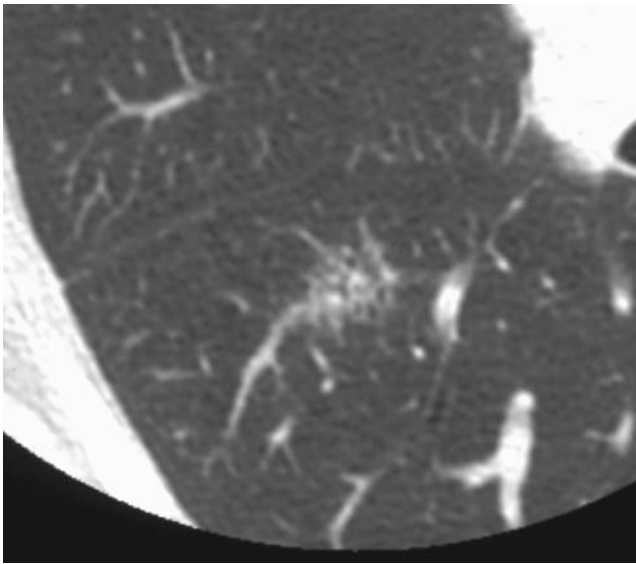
Targeted high-resolution computed tomography (CT) of the right lower lobe with a slice thickness of 2 mm. Localized ground-glass opacity with a diameter of 12 mm containing an air bronchogram and irregular contour. Original field of view was 12 cm
